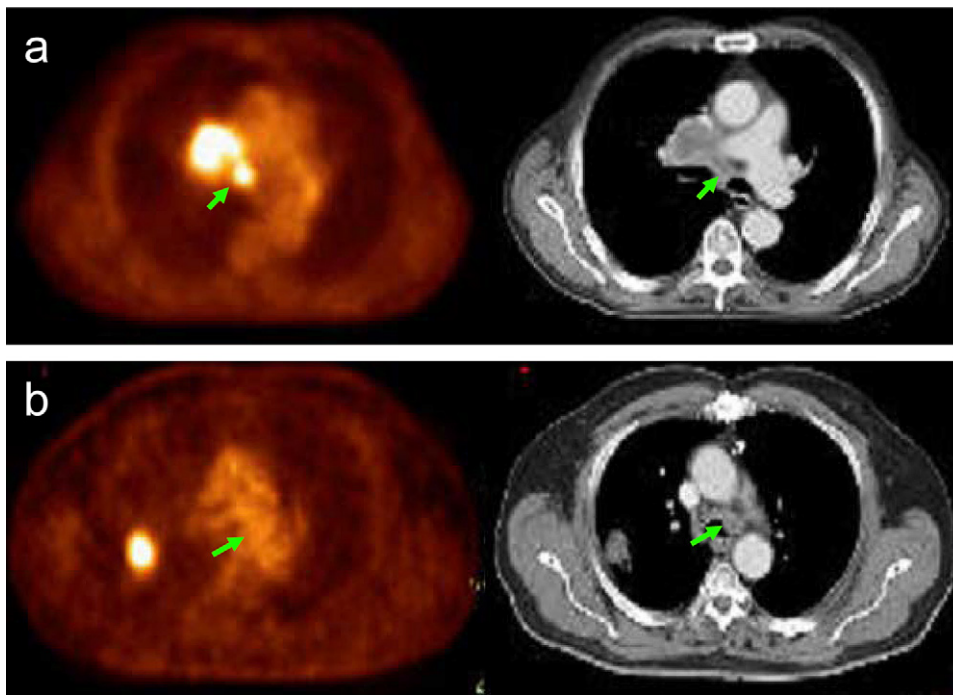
Difference in involved nodal stations between positron emission tomography (PET) and computed tomography (CT). (a) Representative image of patient with positive nodal station 7 on PET, with negative findings on CT. (b) Representative image of patient with positive nodal station 4L on CT, with negative findings on PET.
